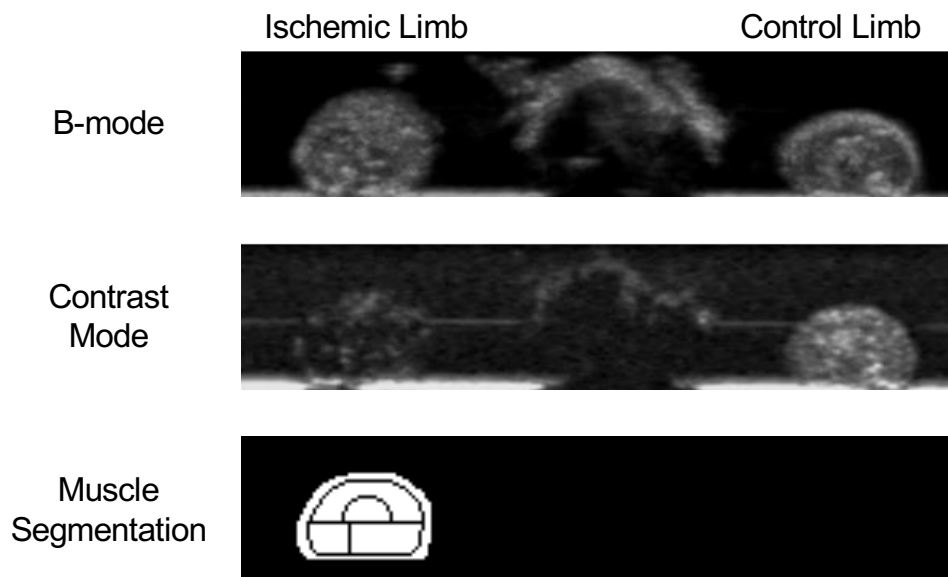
Ultrasound Imaging Setup
